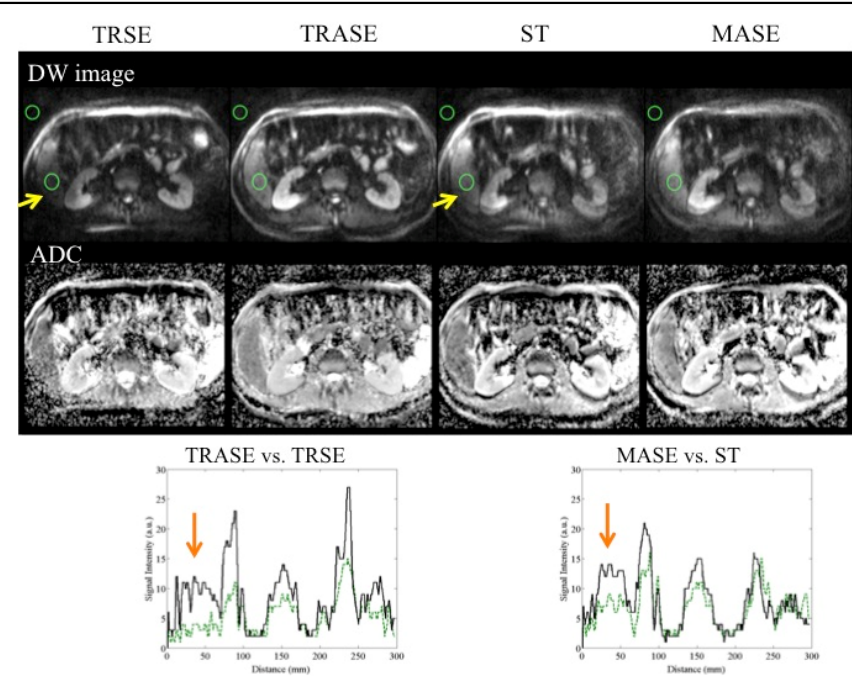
Abdominal DWI acquired in a healthy volunteer at 3T, comparing conventional DWI (TRSE and ST) with adiabatic DWI approaches developed in this work (TRASE and MASE). Top: DW image (b=800). Middle: ADC maps. Bottom: signal intensity profiles along a horizontal line (solid black: adiabatic DWI, dotted green: conventional DWI). Yellow arrows point to signal loss in the liver, which appears to be more severe for conventional DWI (TRSE and ST) than for adiabatic DWI (TRASE and MASE). Orange arrows point to signal increase observed in the liver for TRASE and MASE signal intensity profiles. Green circles represent ROIs used for SNR estimation.
